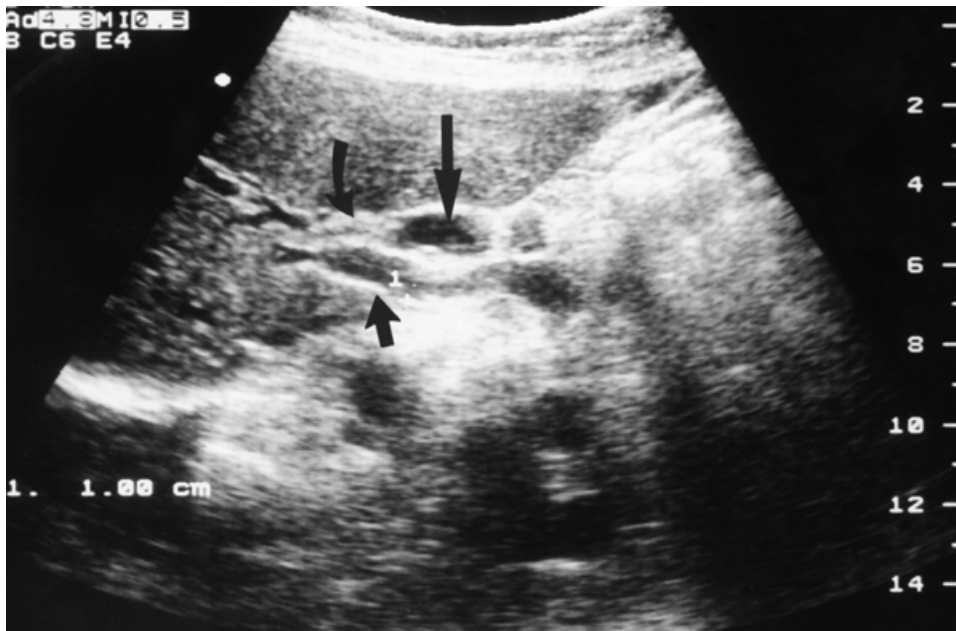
Oblique sonogram obtained during the second sonographic examination shows a cyst-like lesion (long arrow) at the porta hepatis, anterior to the common bile duct (curved arrow). The lesion was mistaken for part of the dilated common bile duct on the initial sonograms. Note that the common bile duct is not shown in its entirety, and only its edge has been shown on this frame. The short arrow points to the portal vein.
